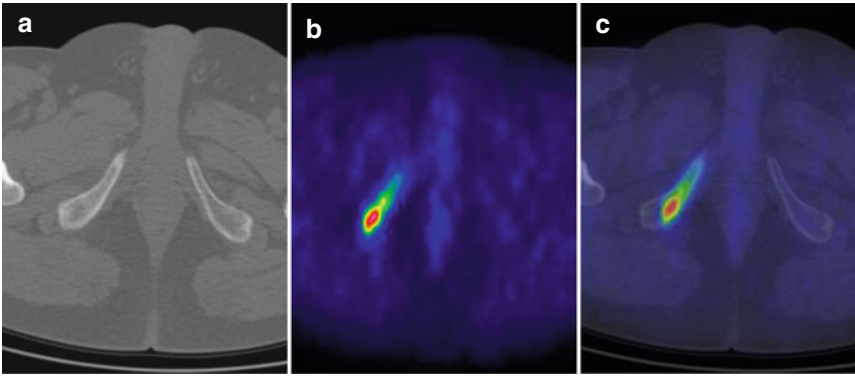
A 75-year-old man treated with radical prostatectomy for prostate cancer (GS 7 (3+4), pT2cN0), who performed  $^{11}\text{C}$ -CHO PET/CT for biochemical recurrence (PSA: 4.00 ng/mL).  $^{11}\text{C}$ -CHO PET/CT showed a pathological uptake in the left iliac bone as documented on CT (a), PET (b) and fused PET/CT (c) transaxial images. After androgen deprivation therapy (PSA: 0.60 ng/mL), helical tomotherapy (HTT) was performed on the positive  $^{11}\text{C}$ -CHO PET/CT lesion. Nine months after HTT, patient showed a complete response with an undetectable PSA serum value
